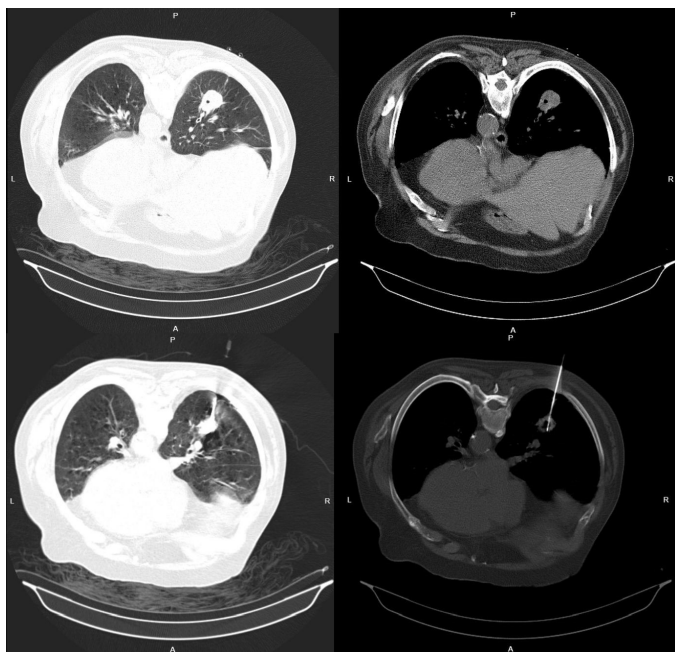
An 80-year-old male patient with a central necrotic thick-walled lesion in the lower lobe of the right lung received the pathological diagnosis of malignant neoplasia as a result of transthoracic biopsy performed in the prone position. During and after the procedure, a mild pneumothorax, which is not clinically significant, is observed in the posterior due to minimal pleural separation.
